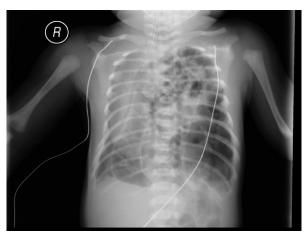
Chest radiograph at initial presentation shows extensive bowel gas in the thoracic cavity, consistent with congenital diaphragmatic hernia.
